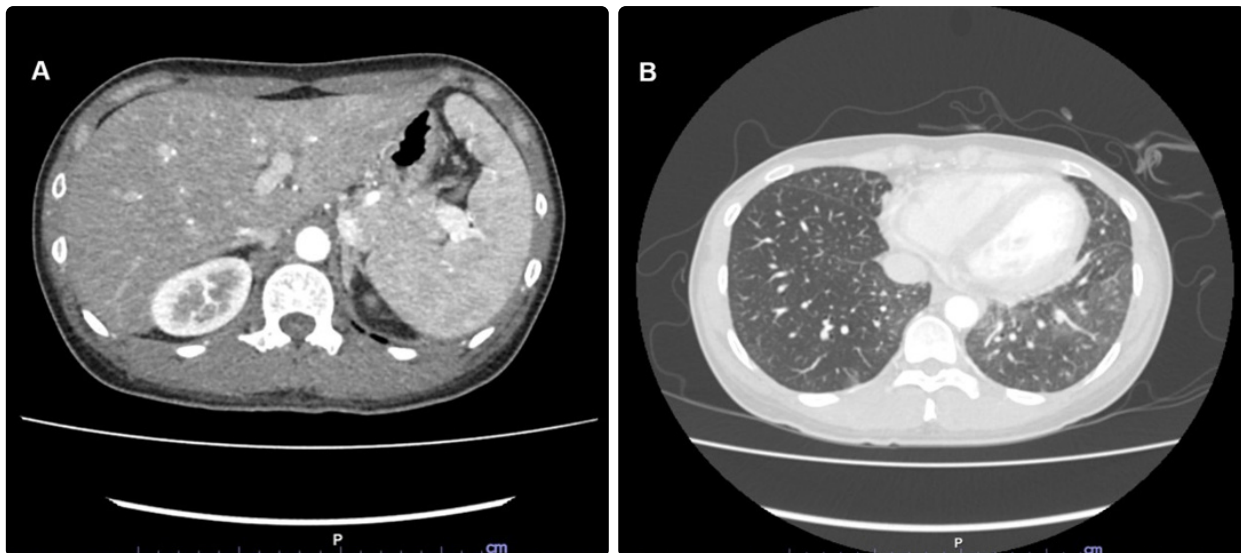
Thoracic and abdominal CT scans showed ground glass opacities in both lower lung fields and lymphadenopathies in the left perihilar, mediastinal, bilateral axillary, supraclavicular and intraabdominal paraaortic nodes, suggesting hematologic malignancies (A; abdominal CT scan and B; thoracic CT scan).
